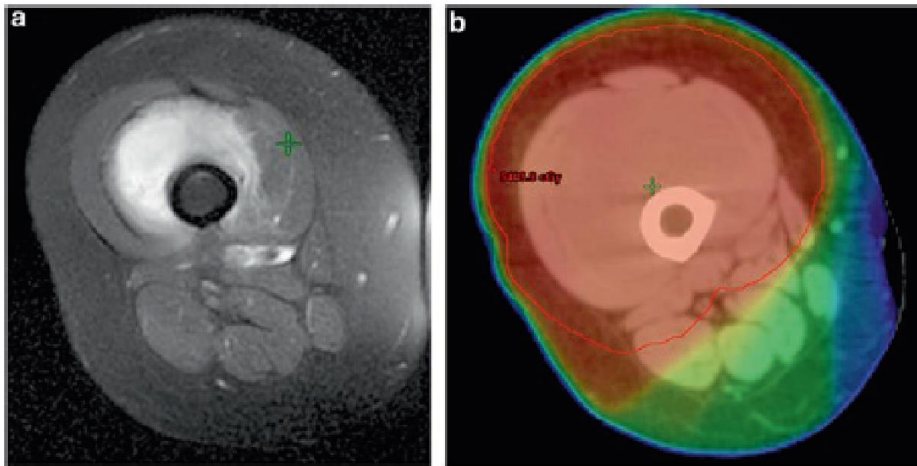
Preoperative IMRT dose distribution: (a) Axial MRI demonstrating anterior thigh STS. (b) Axial view demonstrating the conformal dose distribution of IMRT
